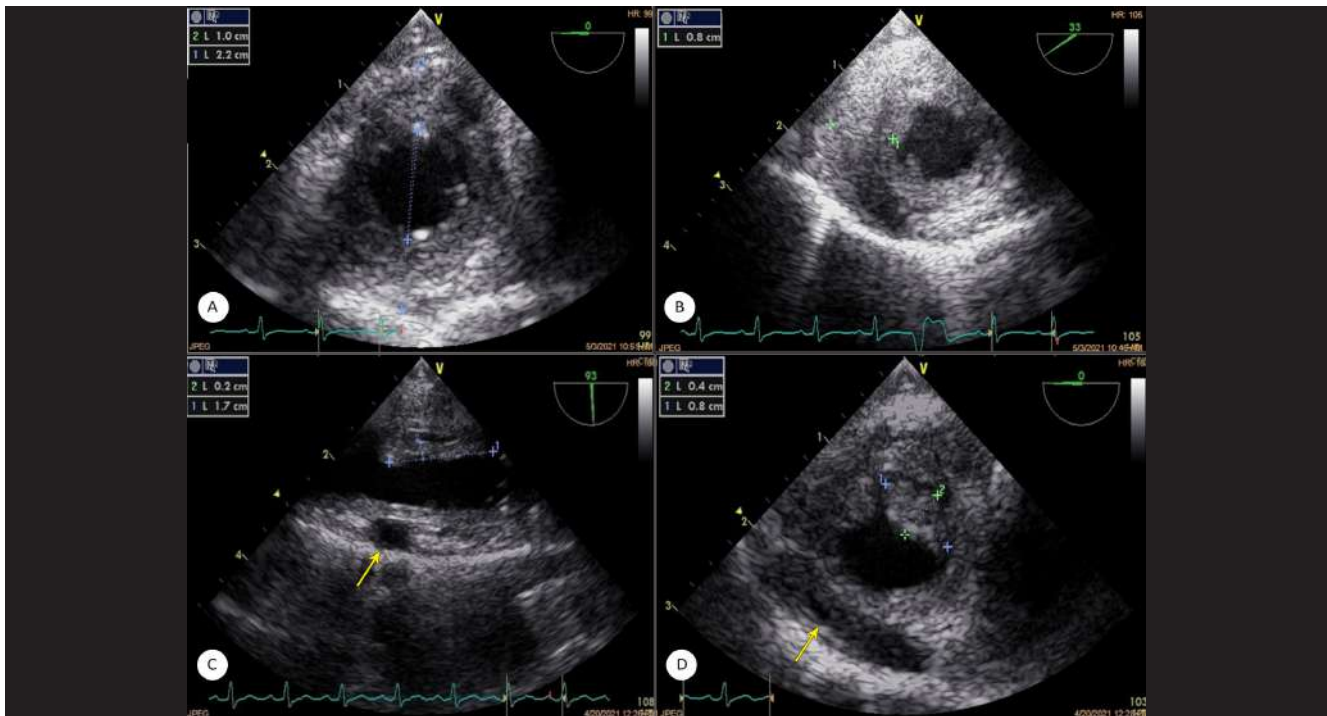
The patient's transesophageal echocardiography is presented herein.
